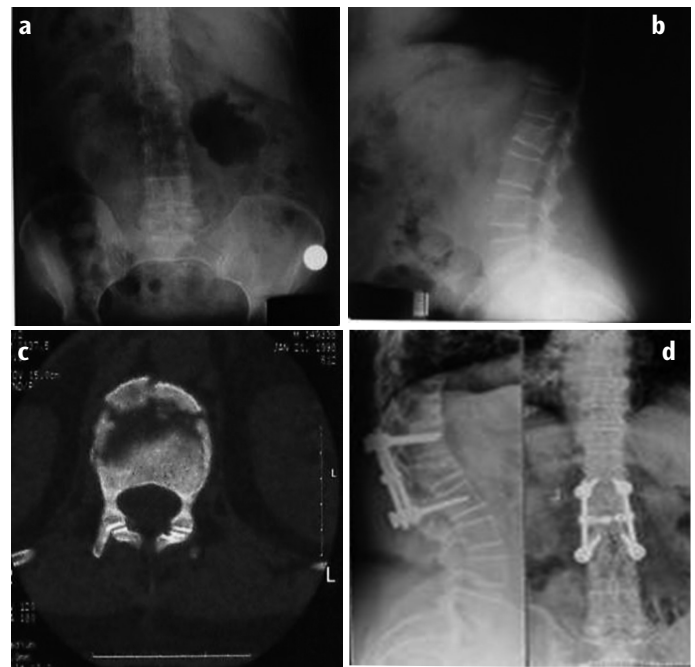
a, b, c, d A 69-year-old female patient was admitted to the emergency department after falling from a height. On physical examination, there was no neurological deficit detected, but there was sensitivity on palpation of the upper lumbar region. Preoperative (a) AP and (b) lateral X-rays as well as (c) axial computed tomography demonstrated an L1 burst fracture. Posterior instrumentation and fusion were performed between T12 and L2 using pedicle screws, and (d) postoperative lateral and AP x-rays demonstrated improvement. Sagittal index, Local Kyphosis Angle, and anterior corpus height loss were 20.5°, 70°, and 42% preoperatively and 15°, 50°, and 26% postoperatively, respectively
